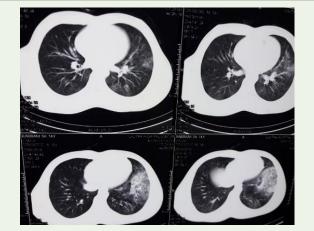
Computed tomography of the chest showing left lower lobe consolidation.
